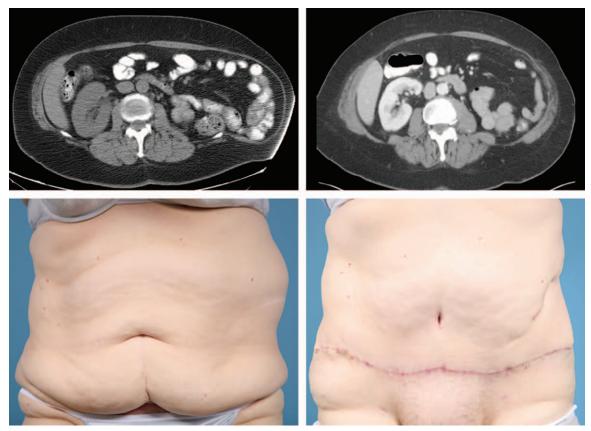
(*Left*) A 62-year-old woman with a true left flank hernia after a nephrectomy, which was repaired with intraperitoneal mesh and a concomitant abdominoplasty. (*Above, right*) Computed tomographic scan at 2-year follow-up reveals maintenance of repair. (*Below, right*) Six-month photographic follow-up shows improved lateral abdominal contour.
